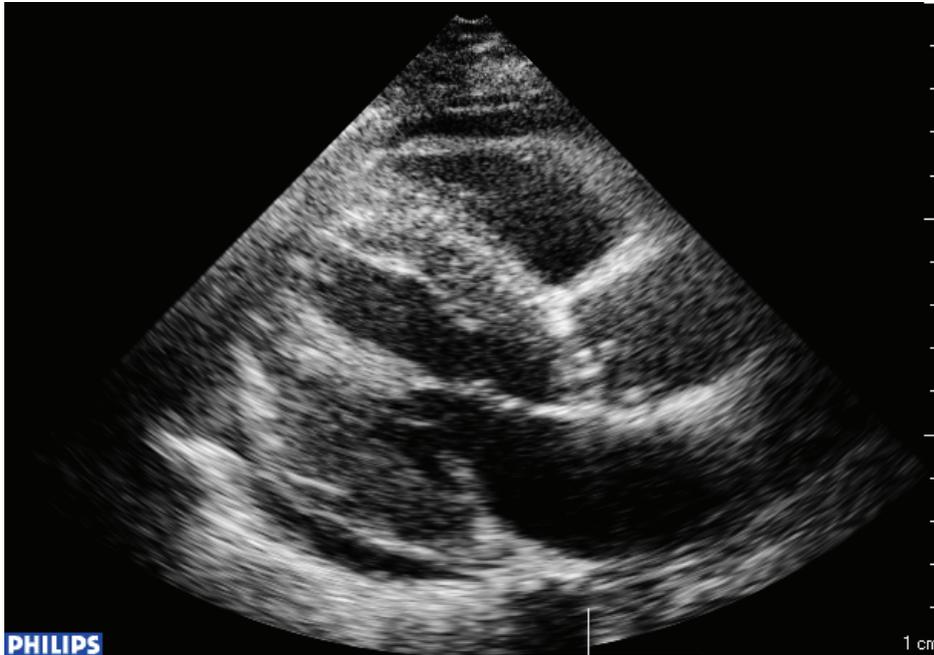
Echocardiogram of RA patient AM female, age 58 - pericardial effusion
